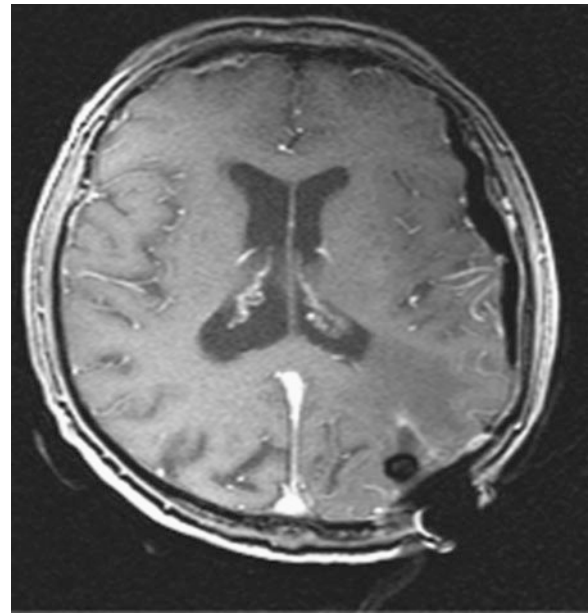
Axial T1-weighted contrast enhanced MRI demonstrating the complete resection of an enhancing left occipital brain metastasis. The area of signal loss in the resection cavity represents bone wax that was placed adjacent to an area that was felt to be suspicious for residual disease by the surgeon. Notice the degree of “brain shift” over the left cerebral hemisphere that is the result of cerebrospinal fluid loss after the dura mater has been opened
